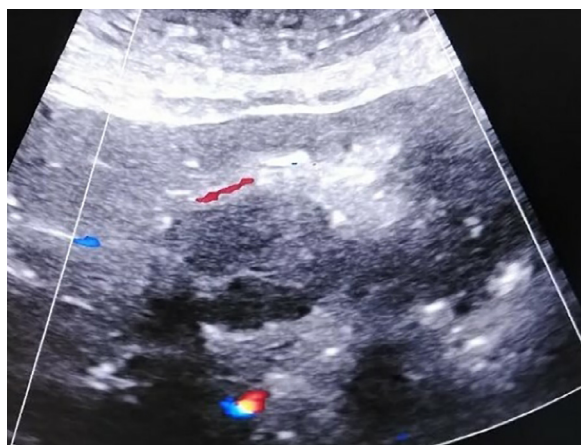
Ultrasound image showing a round, well-limited, lobulated, hypoechoic mass of the pancreatic body.
